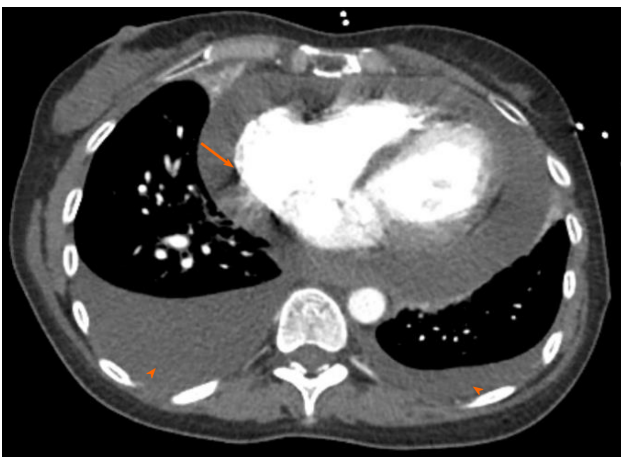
Chest computed tomography angiogram revealed a large pericardial effusion (arrow); moderate right and small left pleural effusion (arrowhead).
